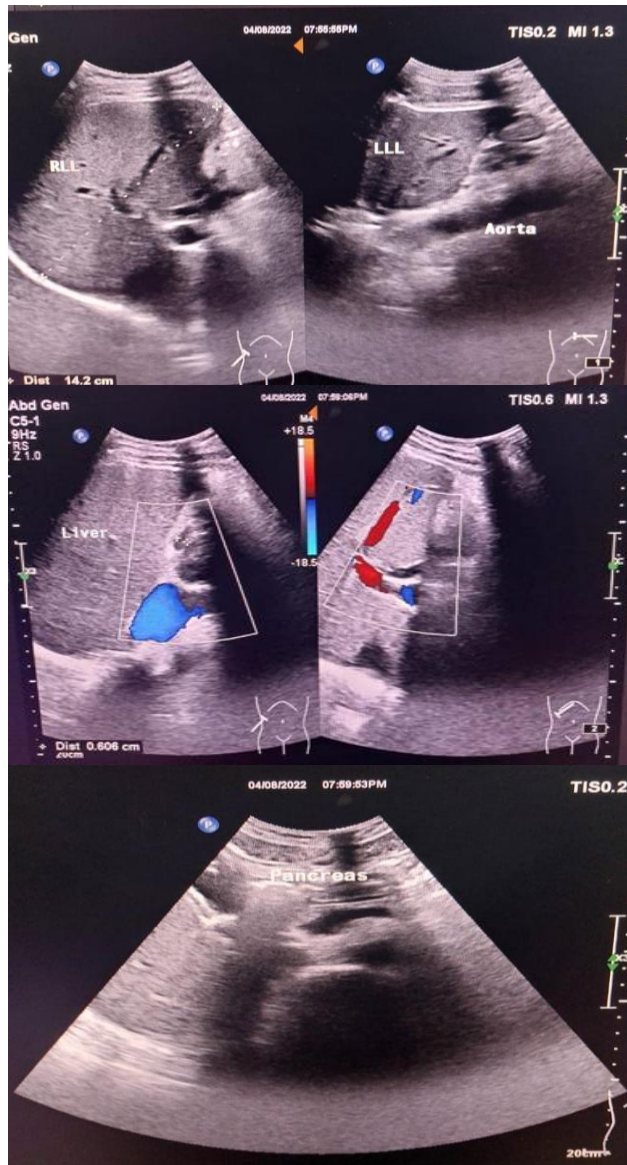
Ultrasound showed normal liver and pancreas size, no stones or gall bladder.
